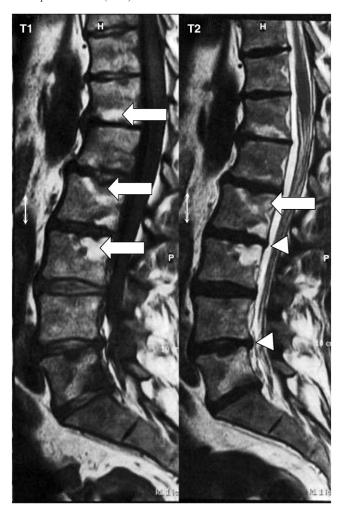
Magnetic resonance T1-weighted (left) and T2-weighted (right) images of the lumbar spine demonstrating Modic type II changes (arrow) and intervertebral disk bulging (arrowhead).
